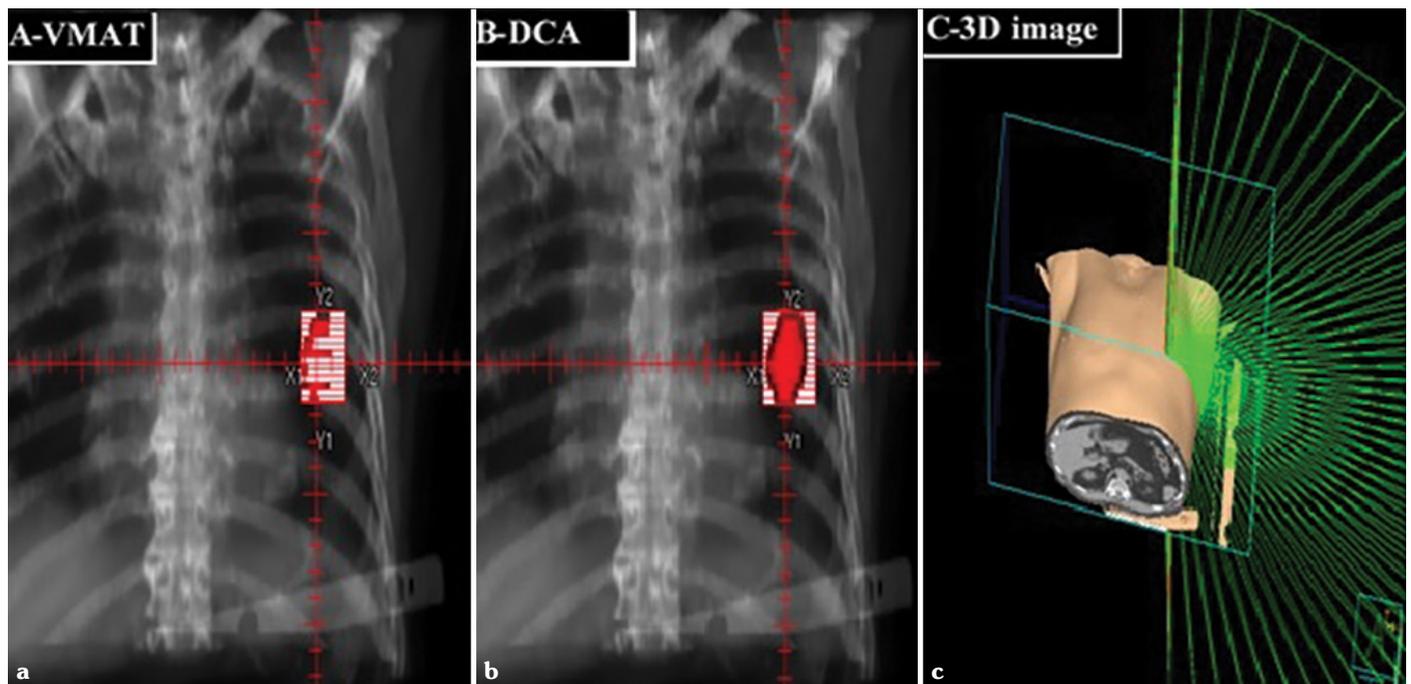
(a) For VMAT technique and (b) For DCA technique; Digitally Reconstructed Radiograph of MLC control point on beam eye view (one control point for arc #1 on each plan). The red color volume represents of tumor. (c) 3D image of arcs on a sample patient. The green color lines represent of beams into body
